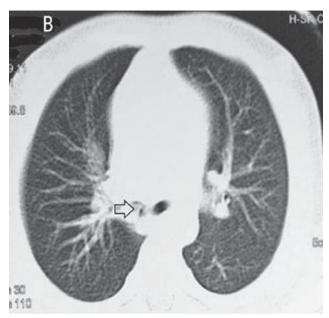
Preoperative chest thin-layer computed tomography (CT) scan showing pulmonary hyperinflation with a big peanut in the right main bronchus; CT shows clear location, shape and volume of the peanut (arrow) in the right main bronchus; CT coronal scan (A); CT axial scan (B).
